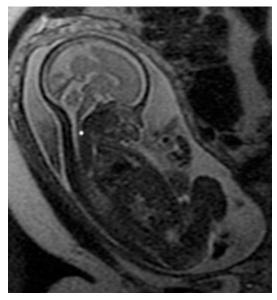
Fetal MRI scan demonstrating severe micrognathia in a fetus with PRS.
